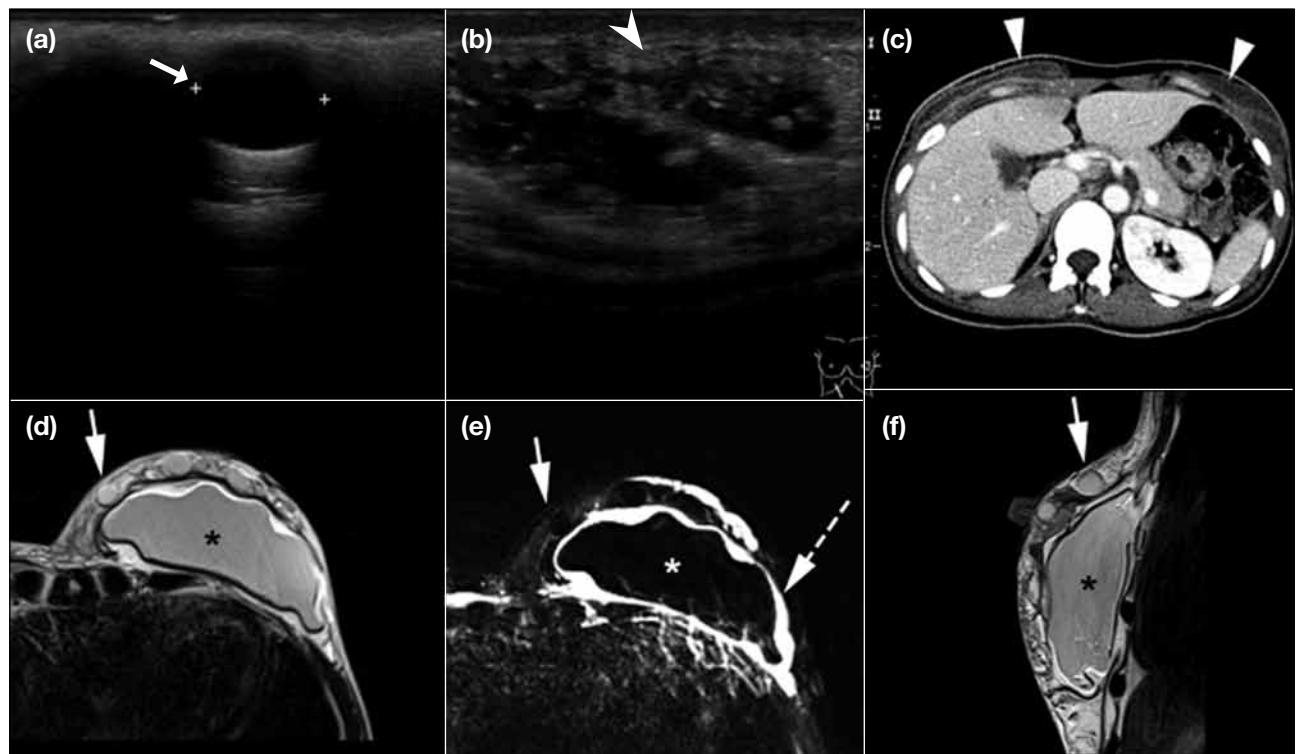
A 48-year-old woman with bilateral silicone implants and silicone injections presenting with upper abdominal wall pus discharge. (a and b) Ultrasound of left breast, (c) axial contrast computed tomography (CT) of the upper abdomen, (d) axial T2-weighted (T2W) turbo spin echo magnetic resonance imaging (MRI) scan, (e) axial T2W MRI scan with silicone suppression, and (f) sagittal T2W turbo spin echo MRI scan. Silicone implant (*) is seen in the left breast showing T2W hyperintense signal (d and f) that is suppressed on silicone-suppression image (e). Multiple subcutaneous nodules (arrows) are seen on (a) ultrasound and (d, e, f) MRI scans with parallel signal to the silicone implant, compatible with free injection of silicone. There is also a rim of T2 hyperintense fluid (dotted arrow) surrounding the left breast implant, corresponding to a known infected collection. Bilateral rim enhancing collections (arrowheads) are seen at the anterior upper abdominal wall bilaterally as shown on (b) ultrasound and (c) CT.
